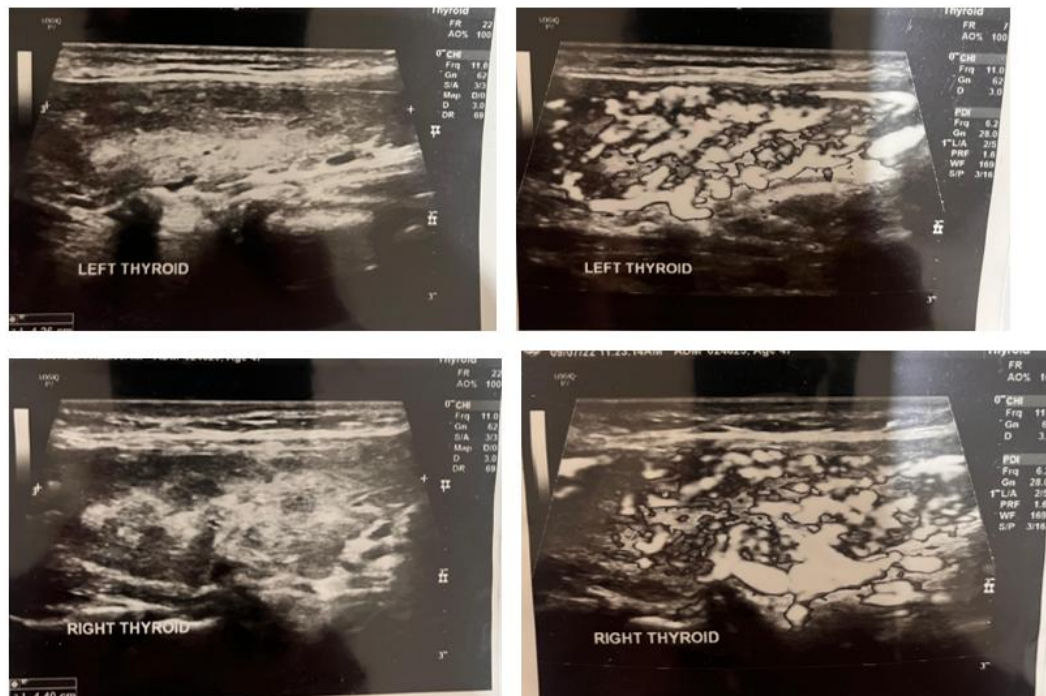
Thyroid Ultrasound
